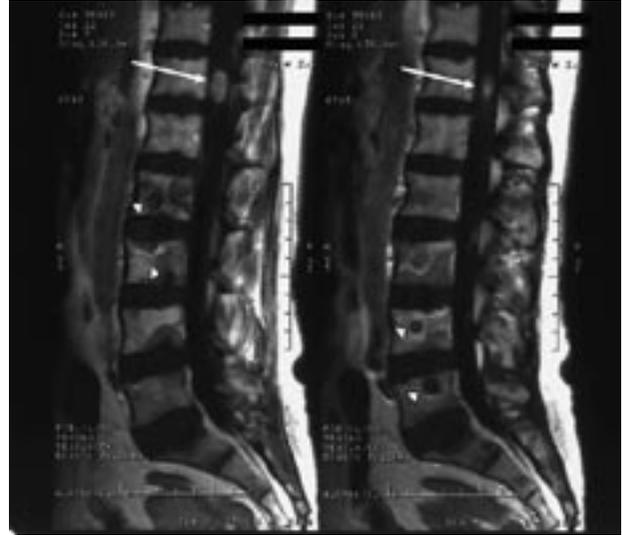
MRI of the thoracic and lumbar spine showing an intramedullary enhancing lesion at the level of the T12 vertebra (white arrows) and multiple lytic bone metastases (arrowheads)
